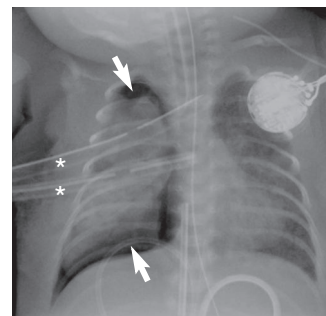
Chest radiograph from an extremely premature infant who has a right-sided pneumothorax (arrows) that persists despite two chest tubes (asterisks). The lung stays partially expanded because it has poor compliance (i.e., it is too stiff to collapse completely). The outline of the visceral pleura and lung is clearly visible because of air in the pleural space. An endotracheal tube and umbilical venous catheter are also present.
